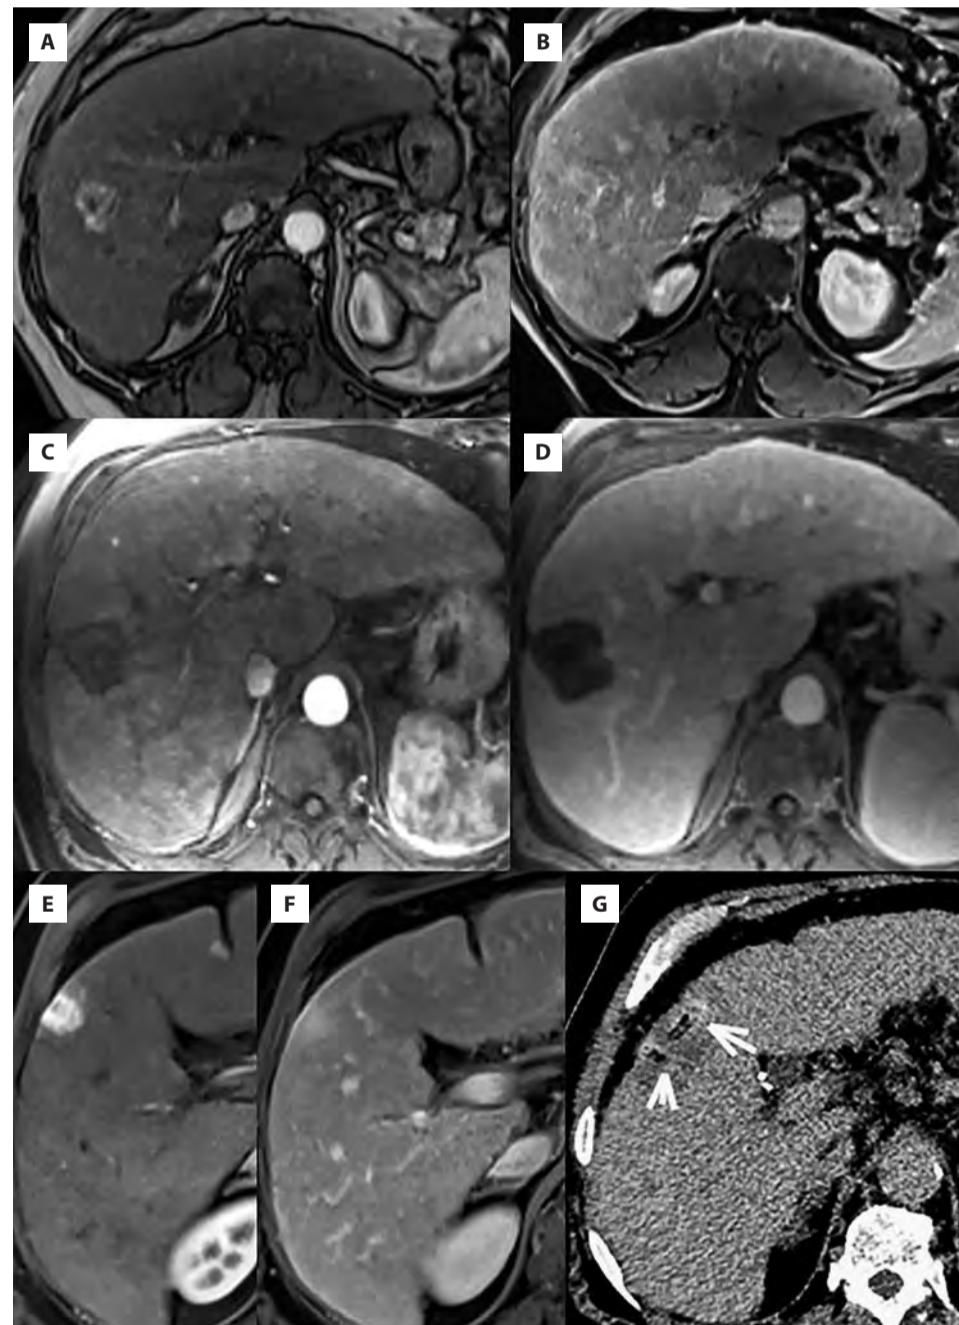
62-year-old male with known history of alcoholic cirrhosis (asymptomatic, ECOG 0, Child-Pugh A5). (A) Axial contrast-enhanced (arterial phase) T1-weighted MR image showing a 3 cm hyper-enhancing right-sided liver lesion with heterogeneous aspect on the portal venous phase without clear wash-out (B). The patient refused surgery and underwent a simultaneous biopsy (which confirmed ICC) and RFA. Axial contrast-enhanced arterial phase (C) and portal venous phase (D) T1-weighted MR image showing the absence of tumour recurrence at 6 years of the initial RFA. (E) The patient developed another hyper-enhancing lesion in segment V with persistent enhancement on the delayed phase (F). This lesion was biopsied and corresponded to another ICC. Patient refused surgery again and was treated with RFA. (G) Unenhanced-CT immediately performed after the RFA showing the adequacy of the ablation zone (arrows).
